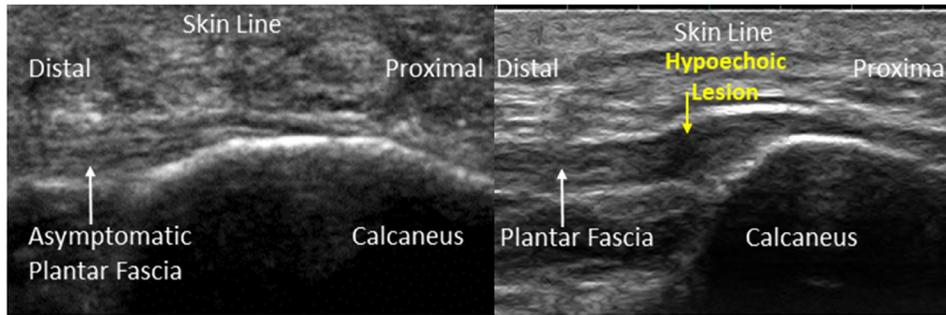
Representative long-axis ultrasound images of the proximal plantar fascia. Normal appearance of asymptomatic plantar fascia (left) and diagnosed chronic plantar fasciitis with hypoechoic lesion, indicating a lack of fascia integrity at the point of pain (right).
